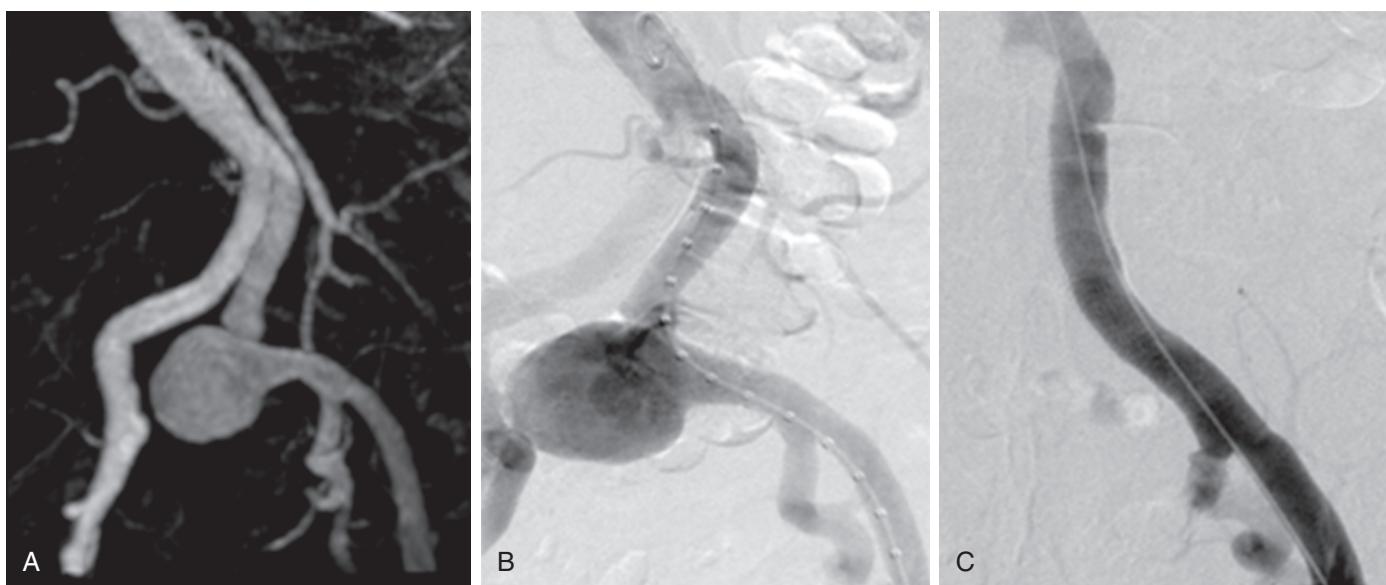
(A) MRI of isolated $3.8 \text{ cm} \times 3.5 \text{ cm}$ left CIA aneurysm, incidentally discovered. (B) Endovascular repair with sizing catheter placed ipsilateral. Angiogram demonstrating proximal and distal landing zones and iliac bifurcation. (C) Two covered stents deployed to seal and exclude aneurysm while preserving IIA. CIA, common iliac artery; IIA, internal iliac artery; MRI, magnetic resonance imaging.
